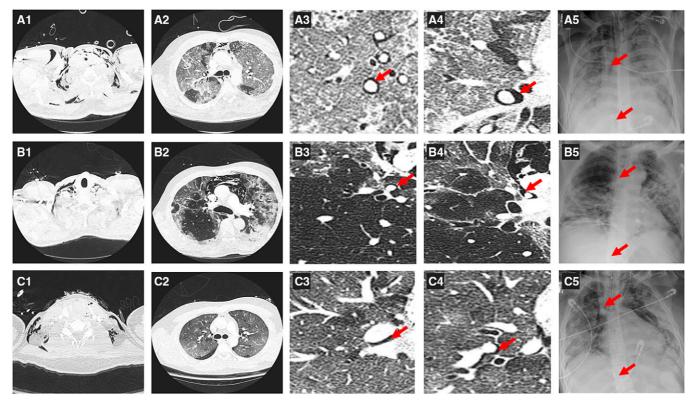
Chest computed tomography axial slices of the three separate patients with coronavirus disease (COVID-19) presenting with spontaneous pneumomediastinum. The figure is arranged in panels representing each patient (*A*, *B*, and *C*). *A1*, *B1*, and *C1* demonstrate subcutaneous emphysema, and *A2*, *B2*, and *C2* show evidence of pneumomediastinum in each patient. *A3* and *A4*, *B3* and *B4*, and *C3* and *C4* show air tracking along the pulmonary vasculature (shown with red arrows) in magnified chest computed tomography axial slices. *A5*, *B5*, and *C5* demonstrate the positioning of the cannulas (located in the superior vena cava and inferior vena cava) for venovenous extracorporeal membrane oxygenation (shown with red arrows) on portable chest radiography.
